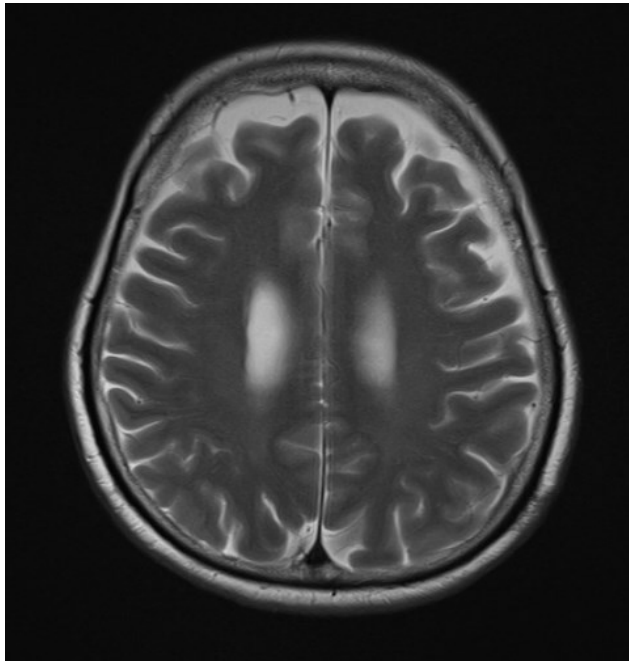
MRI scan, axial T2 sequence show bilateral frontal atrophy
